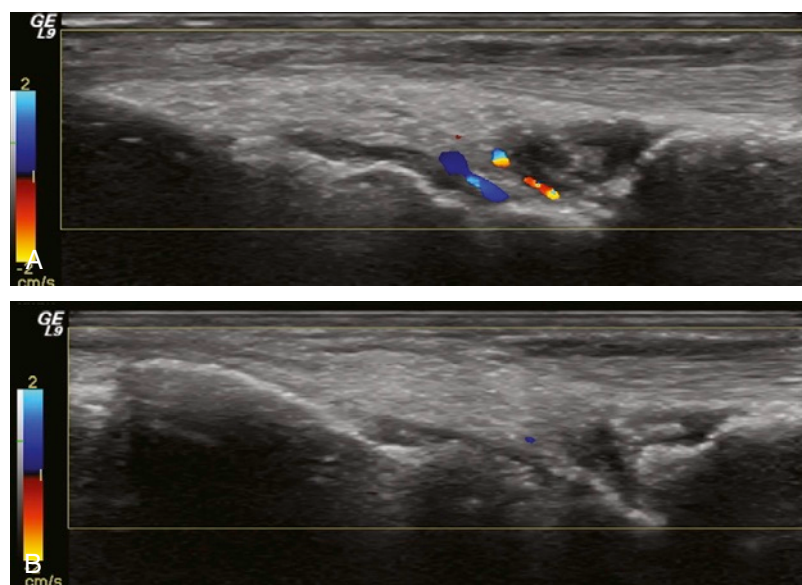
WRIST JOINT WITH SYNOVITIS. A, Light transducer pressure and Doppler activity can be seen in the area of synovial hypertrophy. B, A moderate transducer pressure obliterates the vessels and thereby eliminates flow information. The synovial tissue is also compressed.
